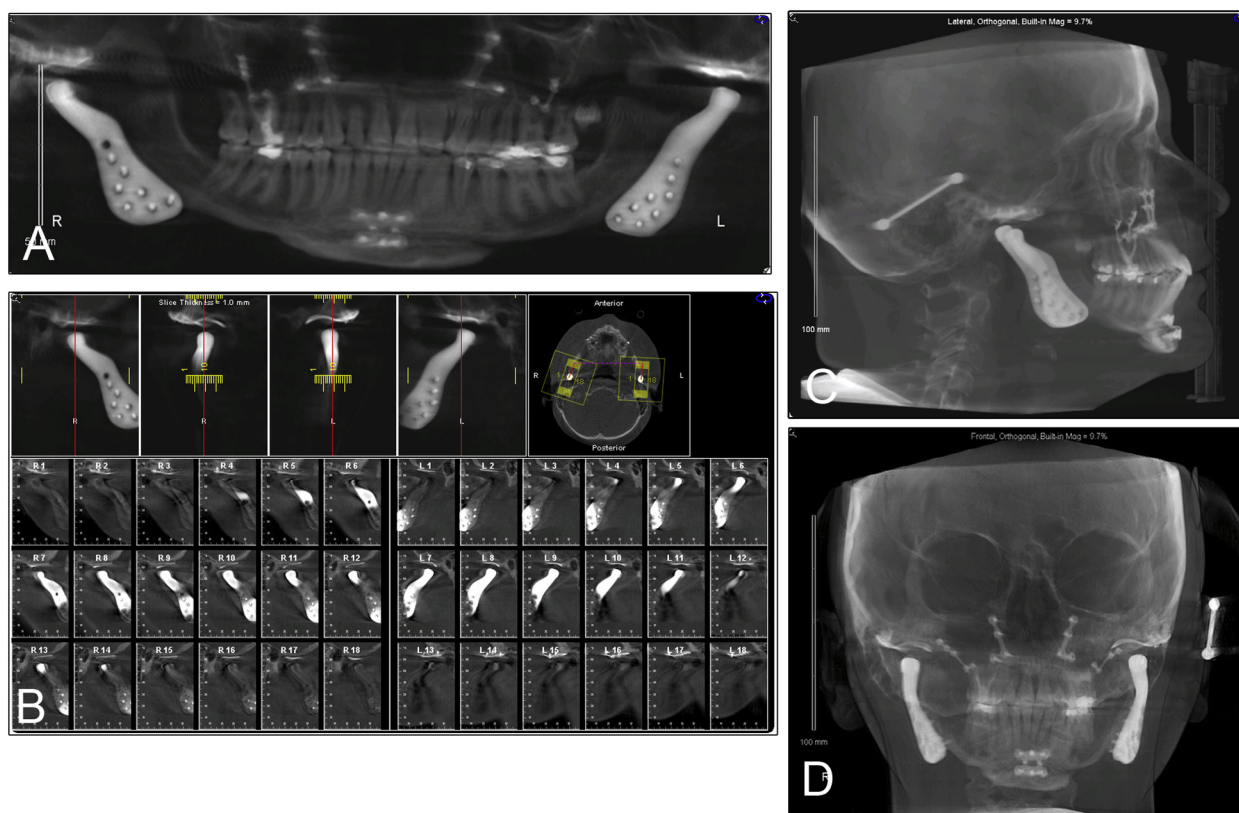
Postsurgical radiographs. A, Panoramic radiograph. B, Bilateral TMJ radiograph. C, Lateral cephalometric radiograph. D, Frontal radiograph.
